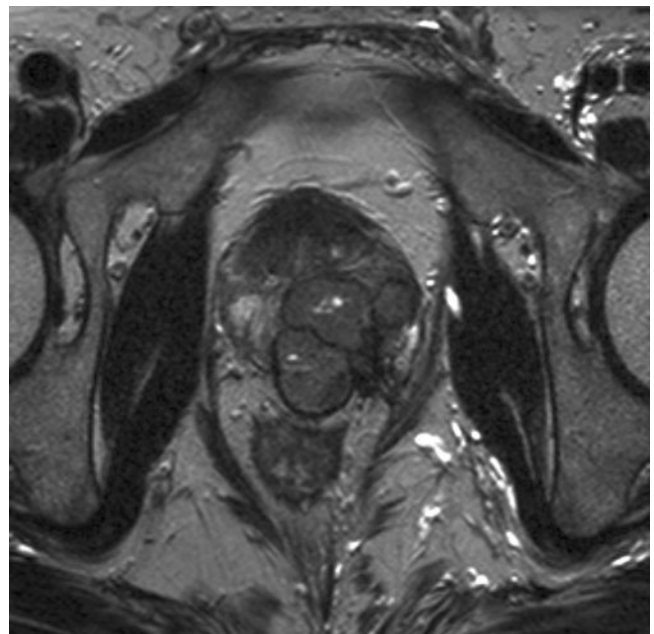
A 45-year-old man with leiomyosarcoma. He presented with urinary retention. His prostate-specific antigen level was 0.3 ng ml^{-1} . A T_2 weighted MR image shows a multilobular low signal intensity mass originating from the prostate. Focal high signal intensity suggesting cystic or necrotic change is also seen.
